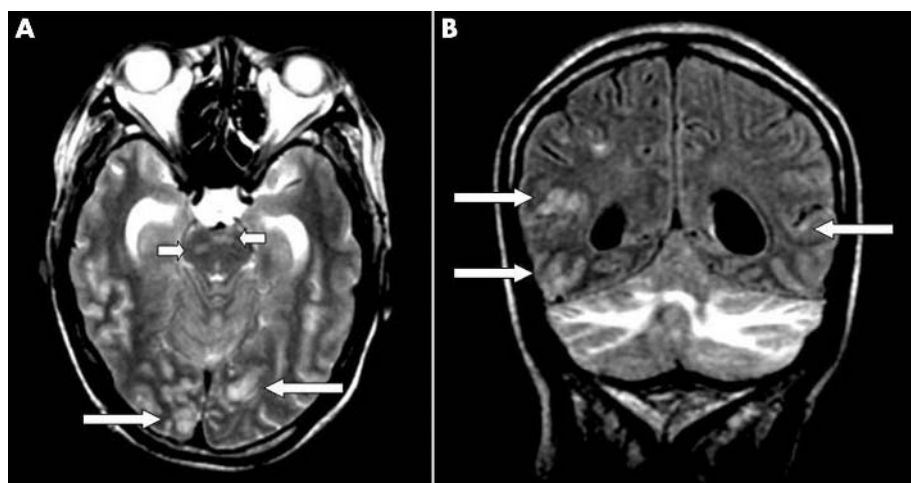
(A) Axial T₂ weighted and (B) coronal fluid attenuated inversion recovery (FLAIR) images showing bilateral abnormal hyperintensities in the white matter of the cerebellum, cortex, and subcortical white matter of the occipital lobes (long arrows), and in the brain stem (short arrows).
